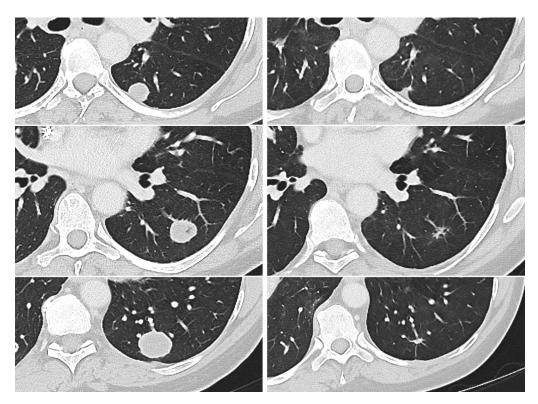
Responses to TIL reactive with neoantigens in colon cancer. Patient with colon cancer metastatic to lungs. Treated with lymphodepletion followed by adoptive transfer of TIL reactive with mutations in *DNMT3A* and *MUC6* and six doses of interleukin-2. The patient had near complete response and had received no other treatment. The left panel is baseline CT scan, and the right is 5-year follow-up showing all residual disease. CT, computed tomography; TIL, tumor-infiltrating lymphocyte.
